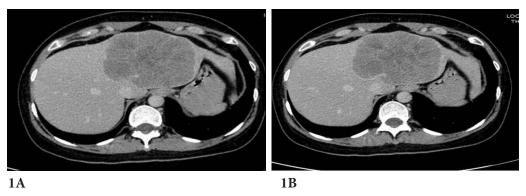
CT scan with contrast showed a lobulated hypodensity enhancing mass with central scar measured 10.7x8.3x7 cm occupied in segment II and IVa.
